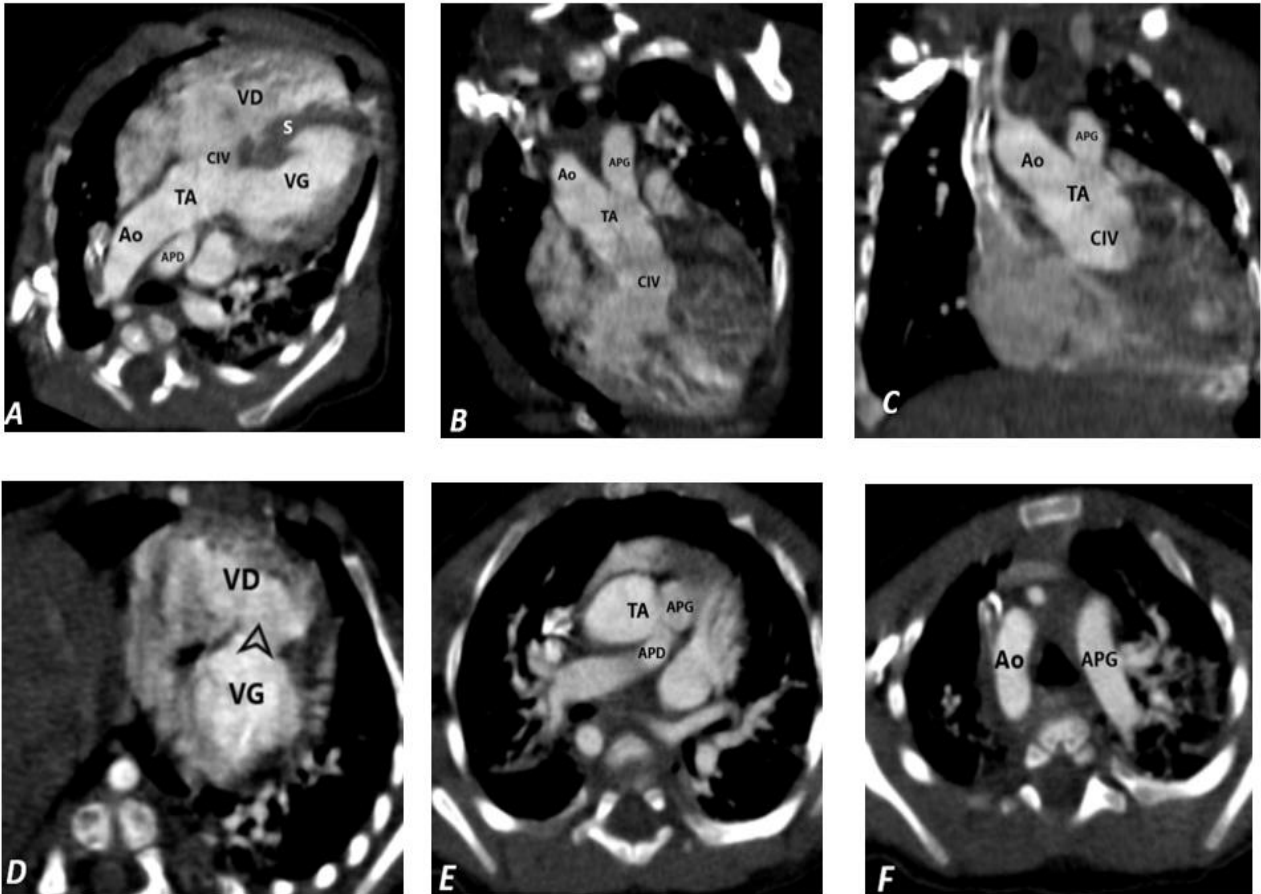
Thoracic CT angiography in the arterial phase: Truncus arteriosus straddling both ventricles above a VSD, giving rise to the aorta and the two pulmonary arteries. A: Oblique axial section nearly parallel to the four-chamber plane; B: Oblique coronal section; C-D: Oblique coronal sections through the interventricular septum plane (C) and axial section close to the short-axis plane (D): VSD (arrow) with anterosuperior location immediately below the truncal valve. E: Axial section: pulmonary arteries emerging from the truncus arteriosus. F: Right aortic arch
